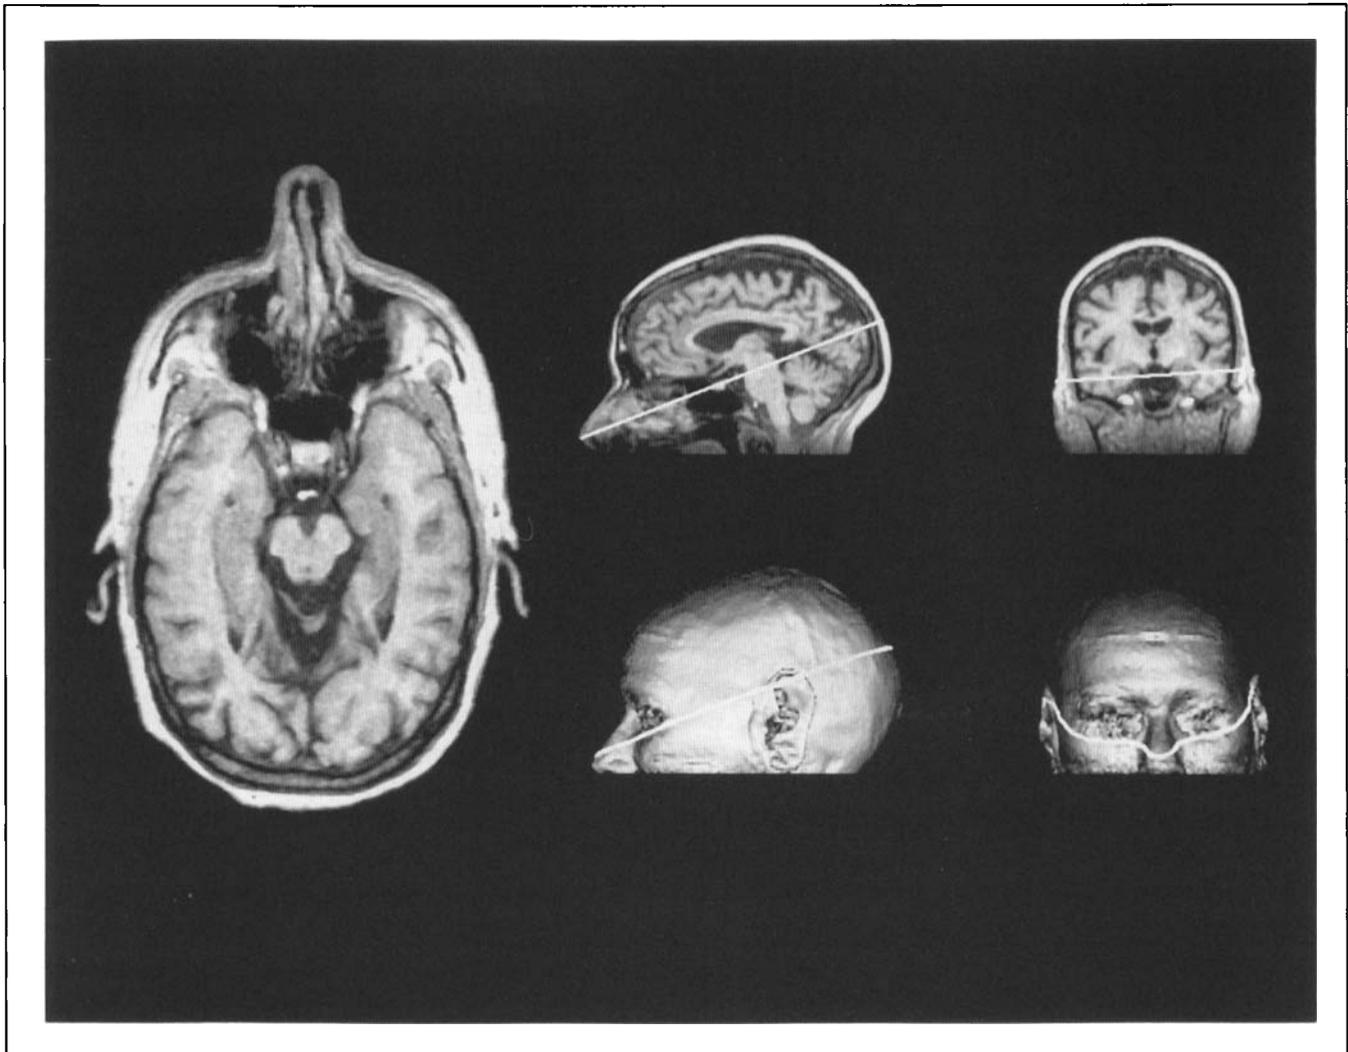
MRI results showing the method of slice selection. The location of the hippocampal slice (left) is shown by a white line in saggital and coronal planes (top right) and on surface renderings (bottom right).
